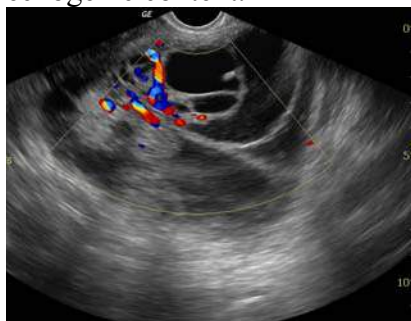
Transvaginal color doppler scan. Same patient demonstrates vascularity within the thick septa.
